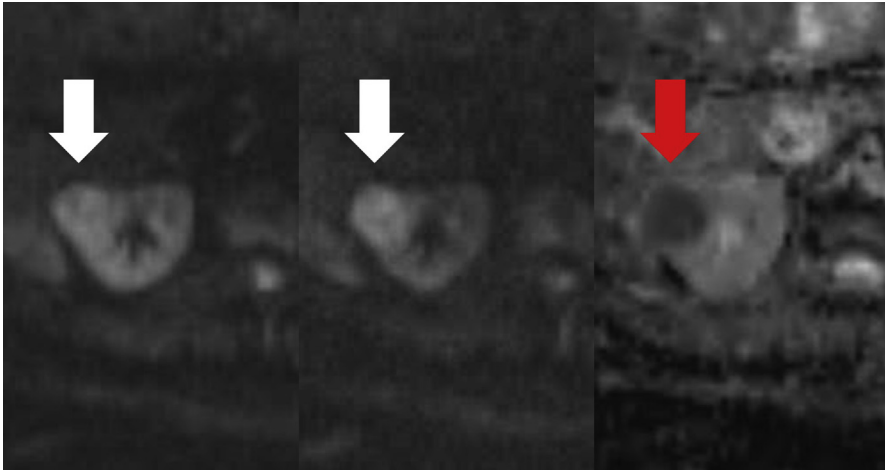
A papillary RCC depicts increasing signal on DWI as the b value increases from 400 to 800 (*white arrows*) compatible with restriction of diffusion with diminished signal on ADC (*red arrow*).
